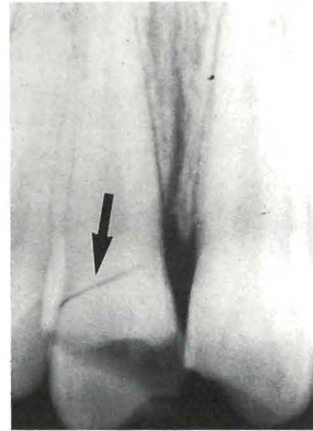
The radiograph of the patient in Figure 7 taken immediately after the accident shows the crown-root fracture line (arrow) of tooth 11.
